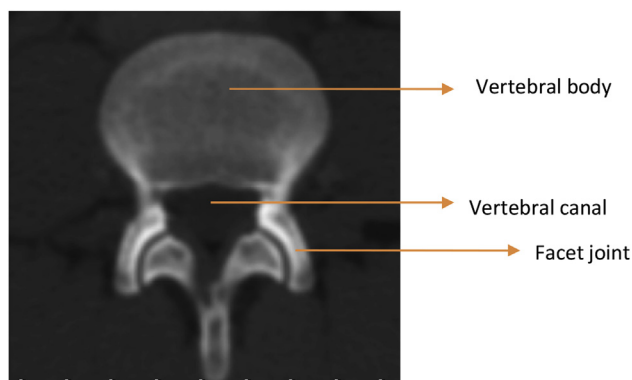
Normal facet joint on CT imaging.
